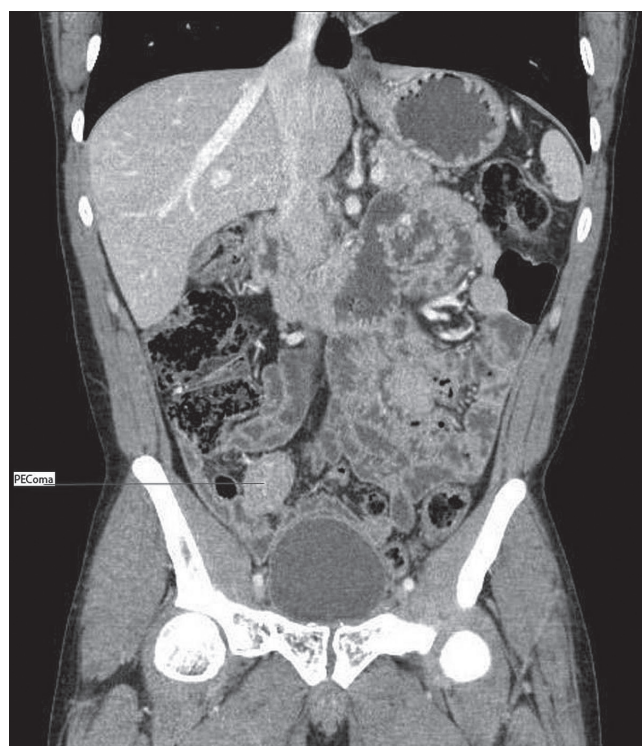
Computed tomography image shows a mass adjacent to the distal terminal ileum.
